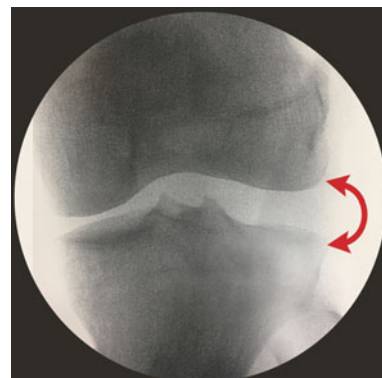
Varus stress X-ray demonstrating a complete lateral sided injury
